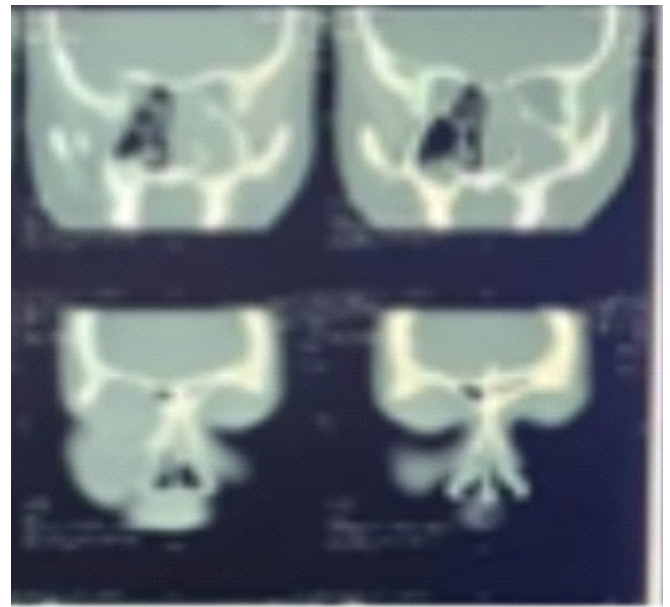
CT-scan showing opacity involving left maxillary, ethmoidal, frontal and sphenoidal sinuses along with mucosal thickening of left maxillary sinus. Obliterated left osteomeatal complex is also seen.
